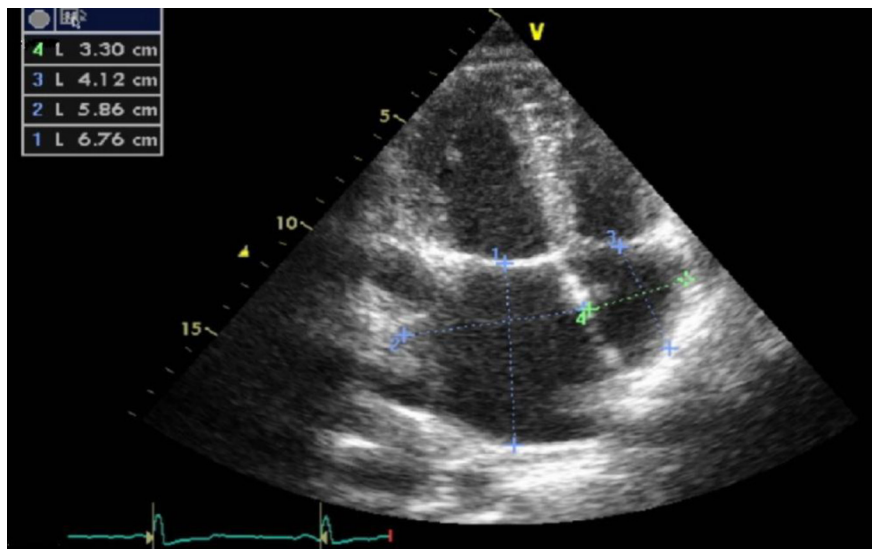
Echocardiographic view of the dilated left atrium
